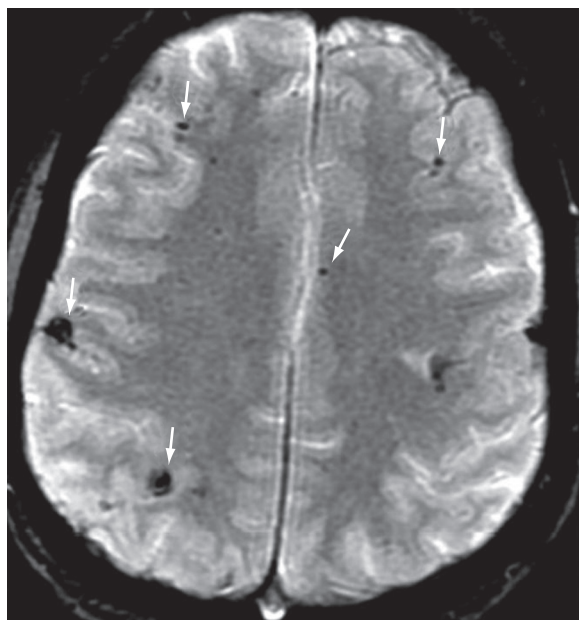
■ T2-weighted magnetic resonance imaging sequence performed at the acute phase of definite mitral valve *Staphylococcus aureus* endocarditis, showing multiple cerebral microbleeds (arrows).
